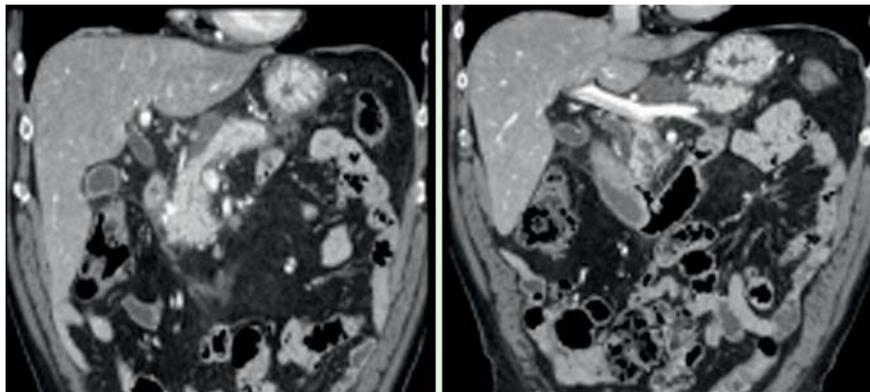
Follow-up computed tomography (CT) (1 month after discharge) showing reduction in the size of the hematoma (2 × 1 cm).
